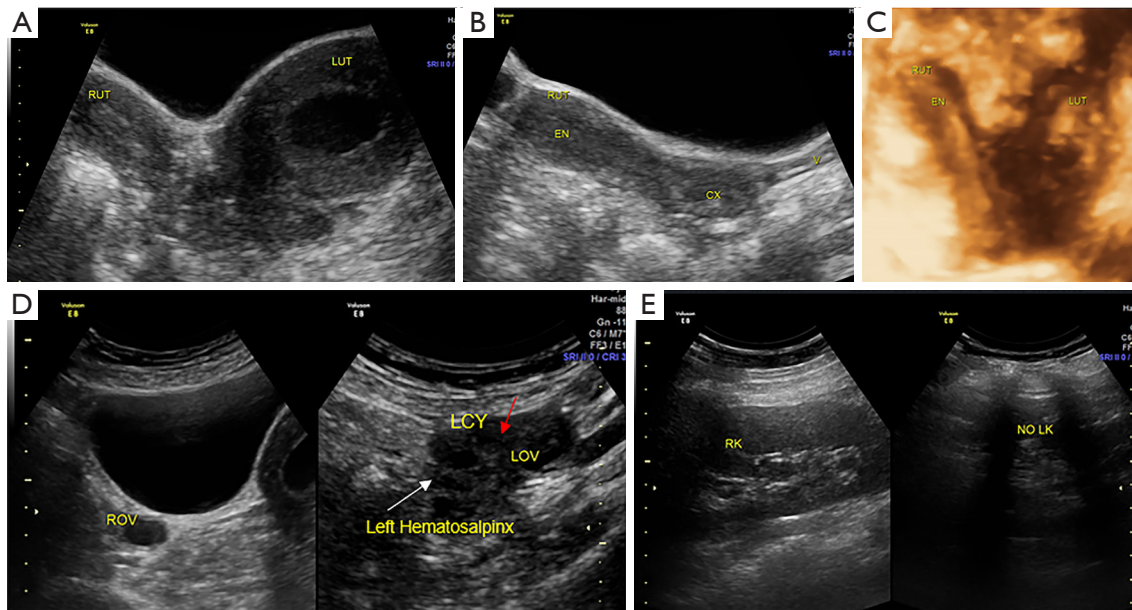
Type V UGTOIRA syndrome: U4a-C0-V0, left isthmus atresia with cavity hematometra and without communicating with right uterus, left completely undeveloped cervix, a normal vagina, left hematosalpinx, left ovarian endometriosis cyst, and left renal agenesis. Sonograms were obtained from a 15-year-old female patient. (A) TAS 2D coronal pelvic plane demonstrating the left isthmus atresia with cavity hematometra, no communication with the right uterus, and a completely undeveloped left cervix. (B) TAS 2D right uterine sagittal section demonstrating a normal uterus, cervix, and vagina. (C) TAS 3D coronal plane of the uterus under stereoscopy demonstrating the left isthmus atresia with cavity hematometra, no communication with the right uterus, and a completely undeveloped left cervix. (D) TAS 2D ovarian sagittal planes demonstrating normal right ovary (left side of the figure), a left ovarian endometrial cyst (a red arrow indicates a low echo), and a left hematosalpinx (a white arrow indicates a meandering low echo) beside the left ovary (right side of the figure). (E) TAS 2D sagittal planes identifying the absence of the left kidney (NO LK; right side of the figure) and a normal right kidney normal (RK; left side of the figure). RUT, right uterus; LUT, left uterus; EN, endometrium; CX, cervix; V, vagina; ROV, right ovary; LCY, left ovarian cyst; LOV, left ovary; RK, right kidney; LK, left kidney; UGTOIRA, unilateral genital tract obstruction with ipsilateral renal anomaly; TAS, transabdominal sonography; 2D, 2-dimensional; 3D, 3-dimensional.
